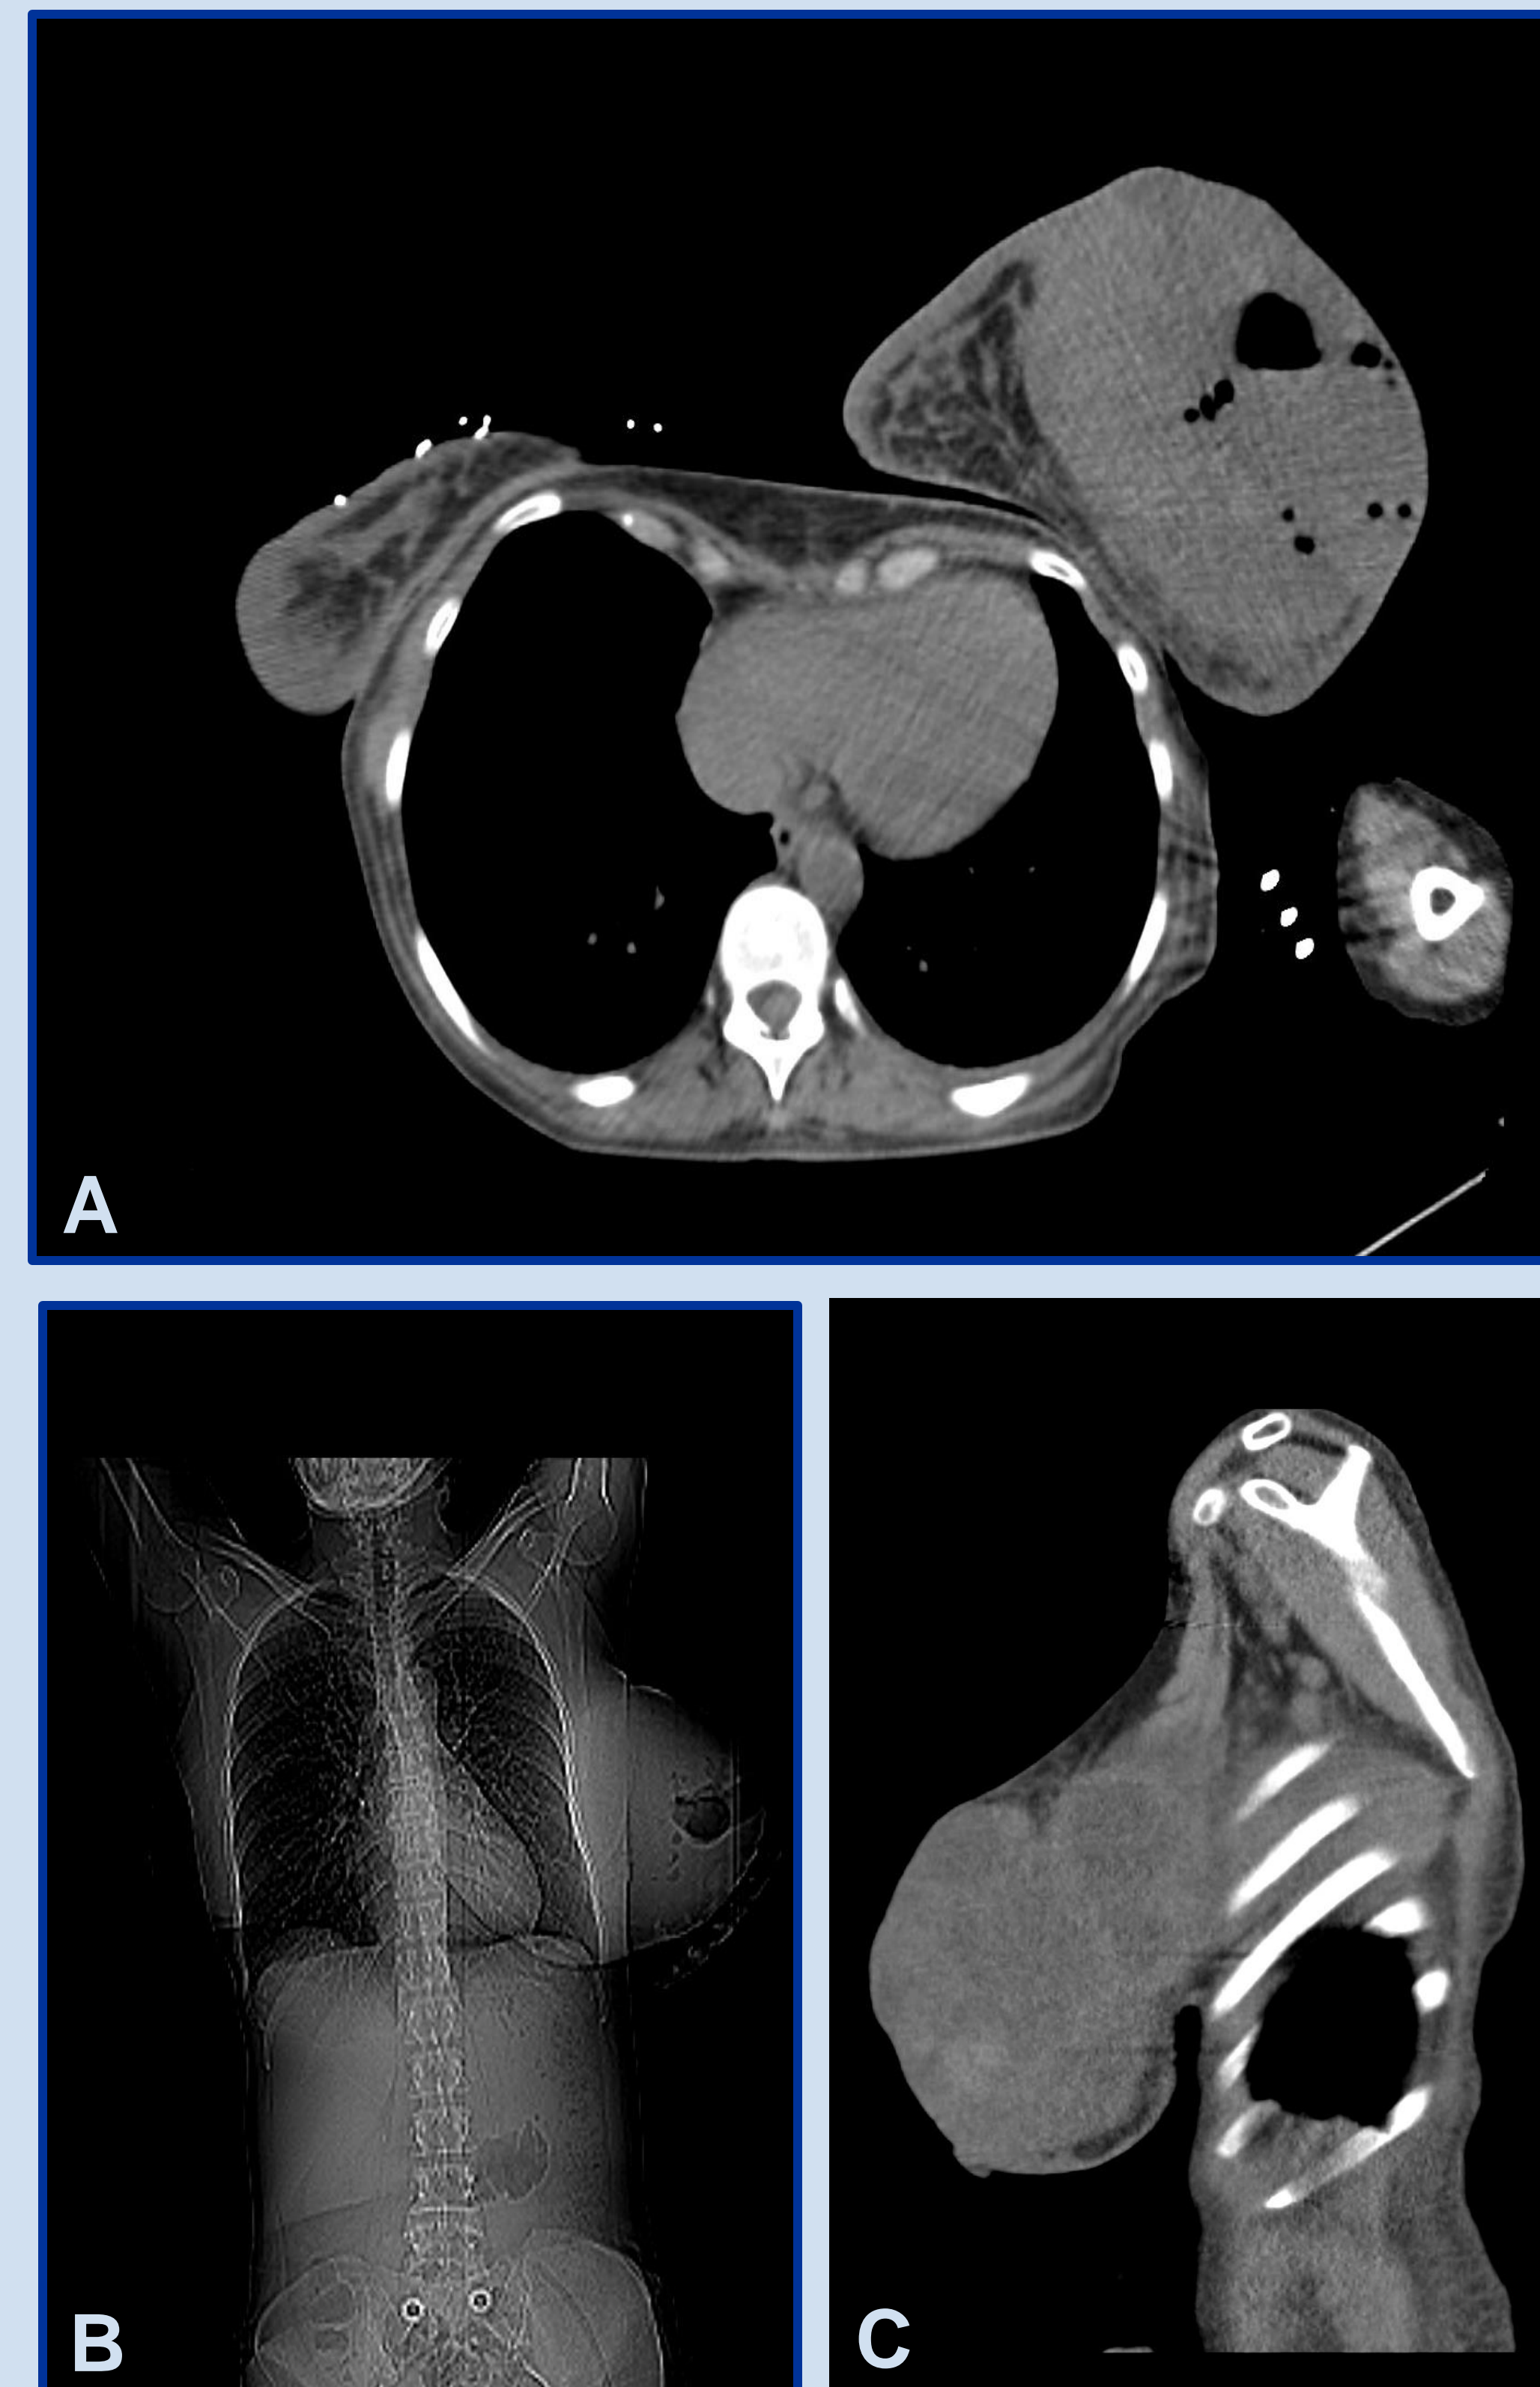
CT Scans (A) Chest (B) thoracic/abdominal (C) sagittal view
